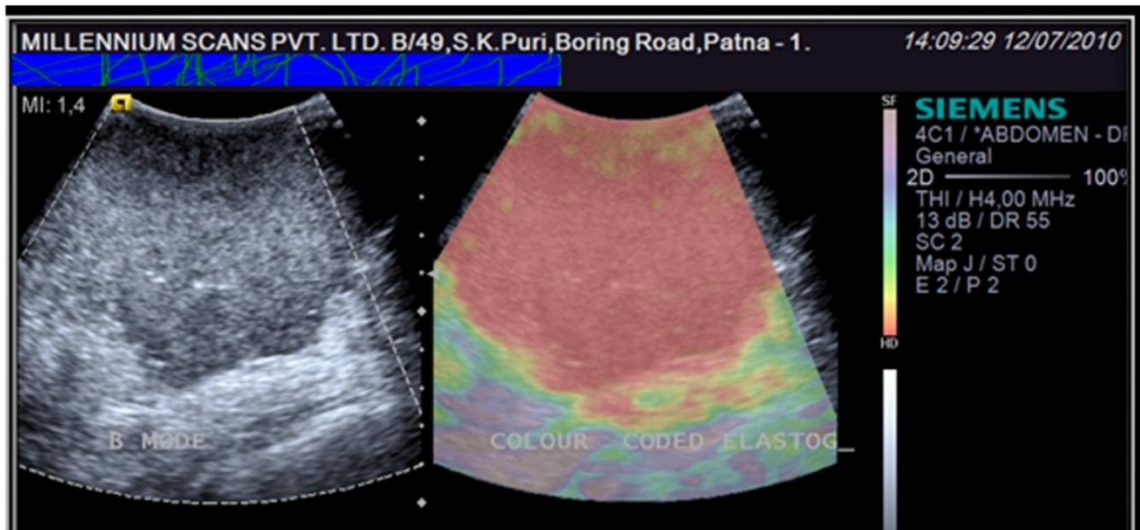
ELASTOSONOGRAPHY OF MALIGNANT BREAST WITH COLOUR CHANGES
